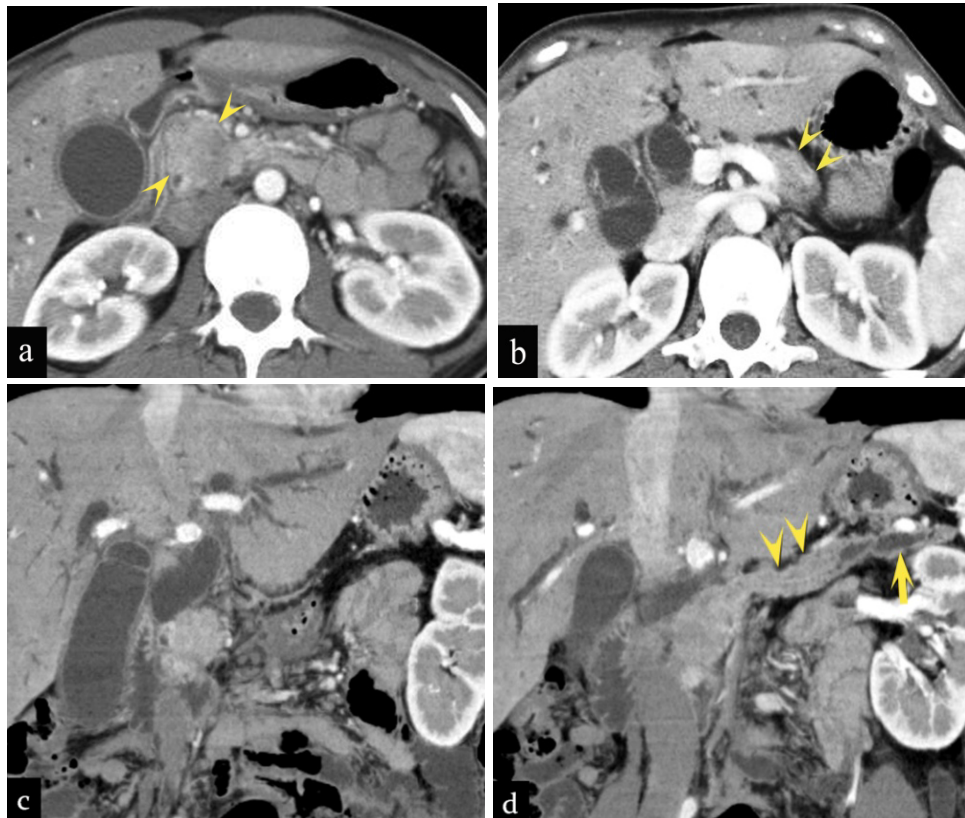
Triple-phase enhanced CT images at the arterial dominant phase demonstrate a well-enhanced mass (arrowheads) on the pancreatic parenchymal phase in the head of the pancreas (a). The pancreatic head grows within the lumen of the MPD (arrowheads) in the body of the pancreas (b). Curved multi-planar reconstruction images (c,d.) obtained at the arterial dominant phase clearly show the extending mass (arrowheads) into the MPD from the pancreatic head tumor. Note the dilatation of the upstream MPD (arrow).
